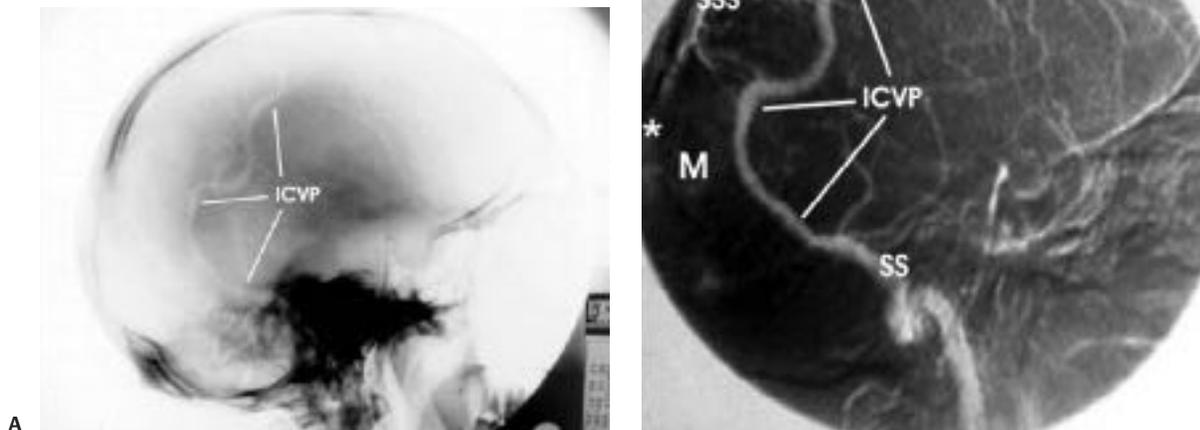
Grade VI parasagittal meningioma located at the posterior third. (A) Plain x-ray; lateral view showing a major intraosseous collateral venous pathway (ICVP). (B) Digital subtraction angiography, venous phase; lateral view showing the venous collateral from midthird of the superior sagittal sinus (SSS) to the sigmoid sinus (SS). Note a complete posterior third SSS occlusion (*). With permission from Sindou M, Alvernia JE. Results of attempted radical tumor removal and venous repair in 100 consecutive meningiomas involving the major dural sinuses. *J Neurosurg* 2006;105(4):514–525.
